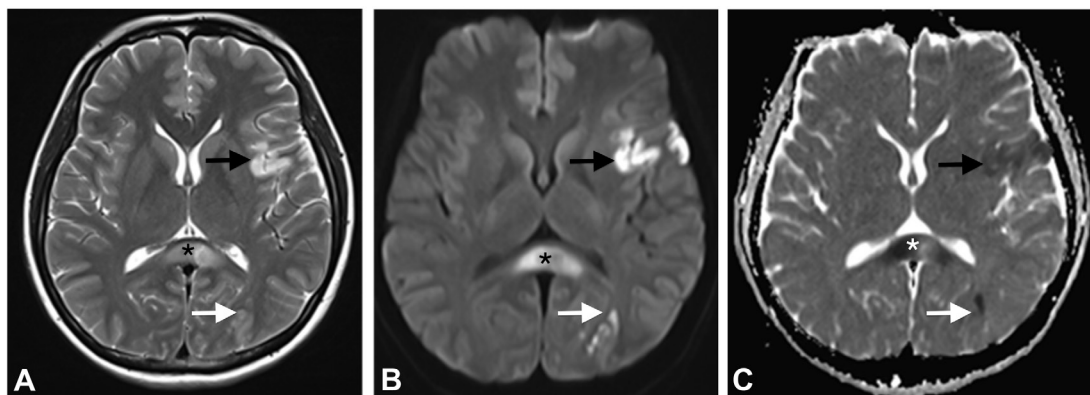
Axial MRI of the brain A) T2 weighted axial view showing multiple hyperintense lesions at left insular (black arrows), splenium of corpus callosum (asterisk) and left occipital regions (white arrows). B) Diffusion weighted imaging and C) apparent diffusion coefficient showing restricted diffusion at those regions in keeping with acute infarcts
